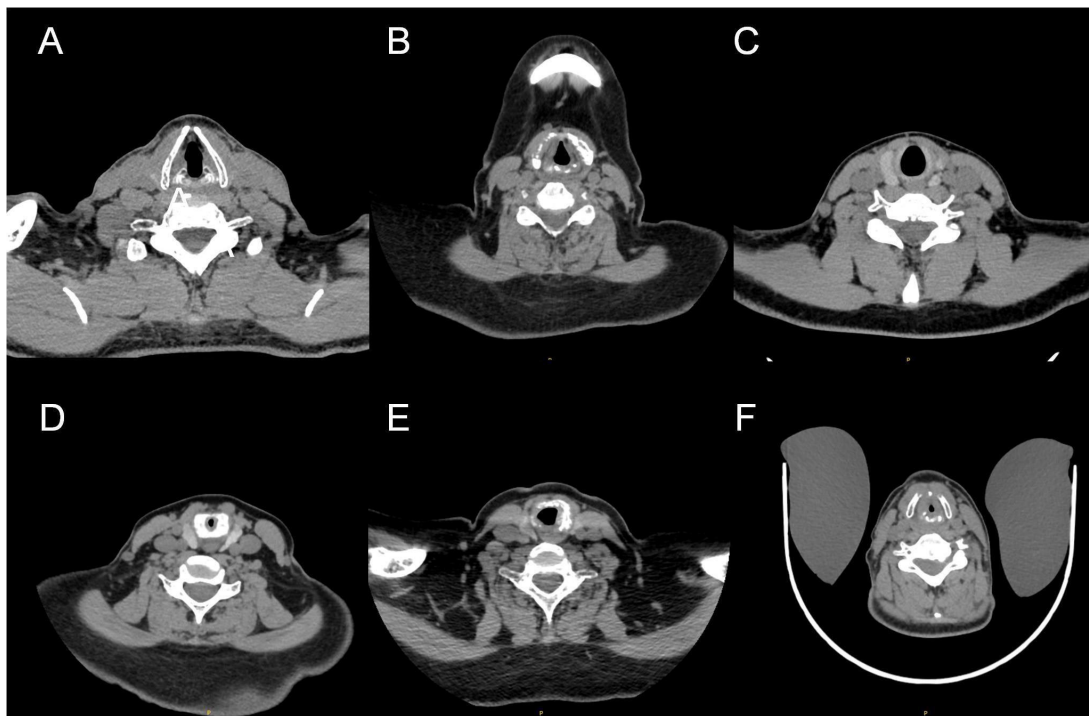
Representative CT images of RP-related laryngeal airway involvement. (A) Normal thyroid cartilage in a 60-year-old male with initial ocular symptoms 18 years ago. (B) Thyroid cartilage destruction in a 58-year-old female with initial cough 5 years ago. (C) Normal cricoid cartilage in a 14-year-old female with initial auricular chondritis 2 years ago. (D) Cricoid cartilage thickening with laryngeal airway stenosis and tracheostomy in a 44-year-old male with initial cough 3 years ago. (E) Cricoid cartilage destruction in the same patient as (B). (F) Significant tracheal mucosal thickening with laryngeal airway stenosis in a 51-year-old female with initial cough 1 year ago. RP, relapsing polychondritis.
